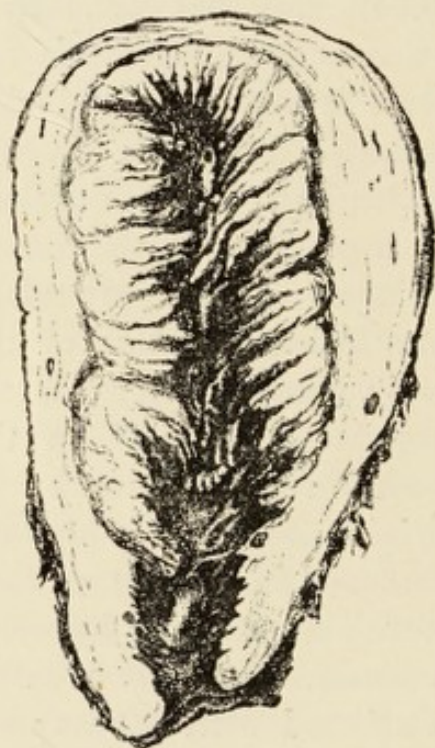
DIFFUSE CANCER OF THE CORPUS UTERI, SHOWING ITS VILLOUS ASPECT. (RUGE AND VEIT.)
